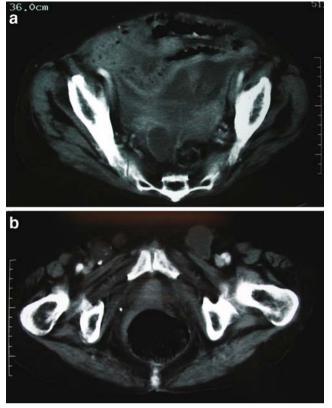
Preoperative CT shows fluid collection in the peritoneal cavity (a) and bilateral femoral and left inguinal masses indicative of hernias, with calcification in the left femoral hernia (b).
